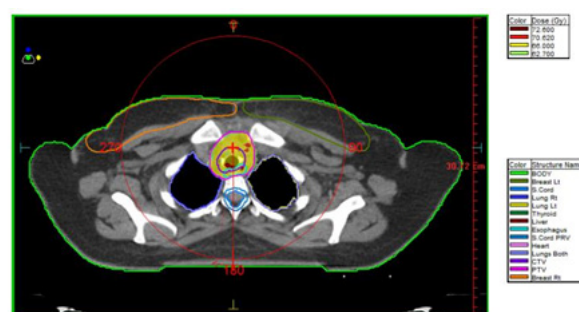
Shows a three dimensional reconstructed AXIAL computed tomography scan of the chest, depicting the radiotherapy plan.
